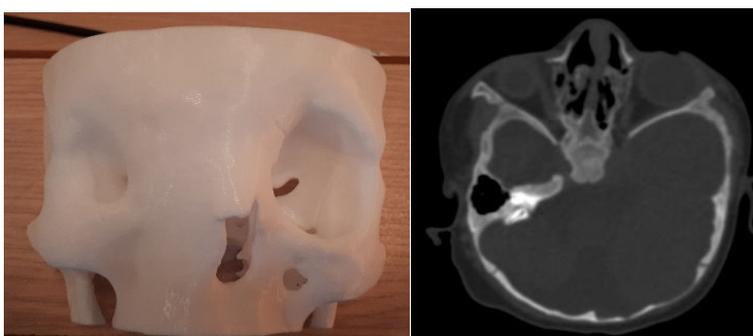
CT scan and 3D model of the orbital anomaly, anophthalmic
